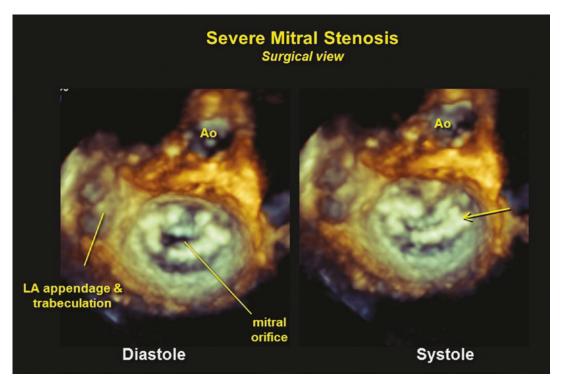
Surgical view of a three-dimensional echocardiogram in mitral stenosis. In this patient, there is marked annular and suprannular thickening and fibrosis (arrows)
